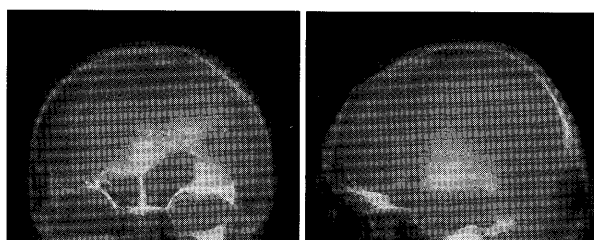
Skull radiographs (*left*: AP view, *right*: lateral view) revealing a high density mass just beneath the left lateral of anterior fontanel. Lucent space between inner table and the tumor suggesting a meningeal osteoma and/or calcified meningioma
